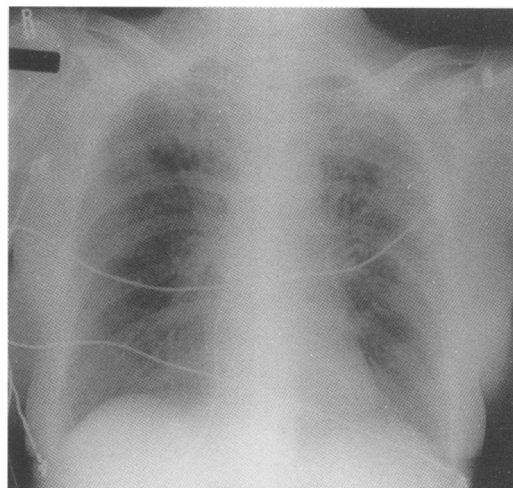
Chest radiograph after treatment with intravenous and nebulised ribavirin showing significant clearing of the pneumonitis.
